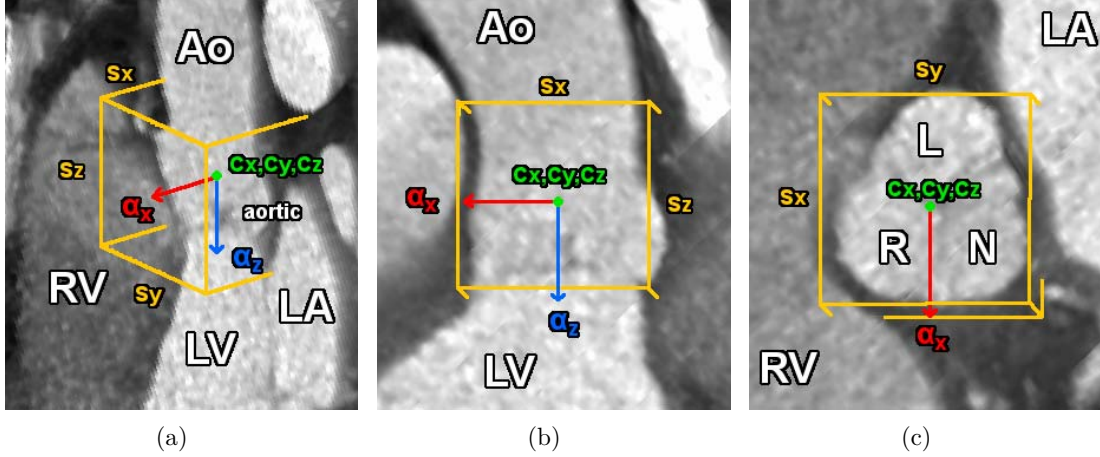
Similarity transform represented as a bounding box around the aortic valve from cardiac CT. (a) Perspective view; (b) Long Axis; (c) Short Axis.
